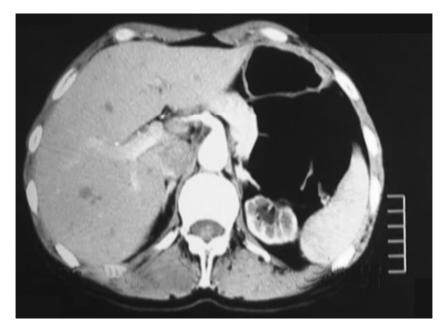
CT showing the tumor situated in the caudate lobe
